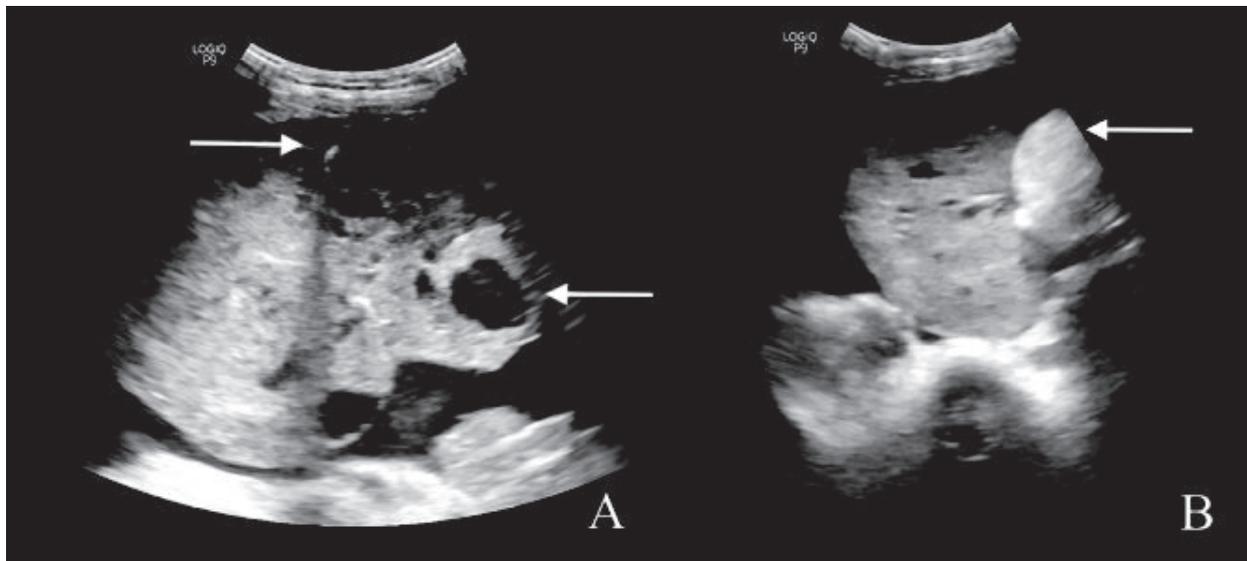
B-mode ultrasound. A. Heterogeneous, predominantly solid, left ovarian mass with internal hypo to anechoic cystic spaces and hyperechoic calcifications. B. Internal hyperechoic sound attenuating fat component is seen. Surrounding ascites is seen.
